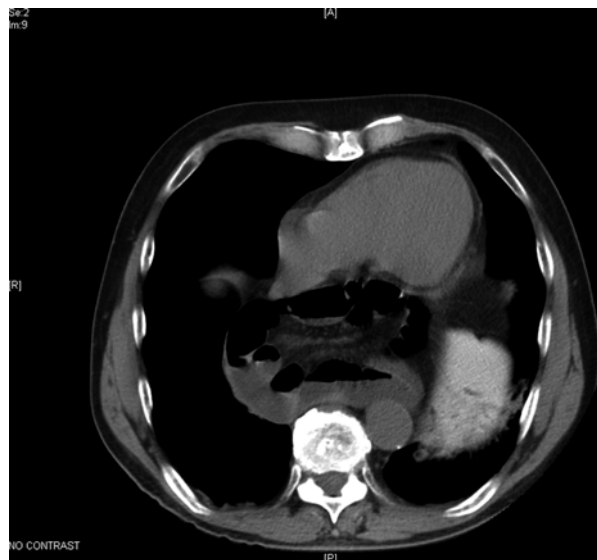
A CT scan is shown of a patient with a type IV hernia with herniation of the small bowel. Loops of the small bowel are present in the posterior mediastinum
